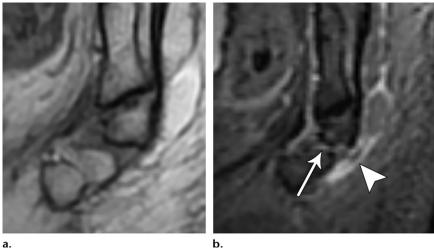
Endplate change in a 34-year-old woman. Sagittal T1-weighted (a) and coronal oblique T2-weighted fat-suppressed (b) images show dorsal subluxation of the coccyx at the first intercoccygeal joint (red dotted line) with T1 marrow hypointensity (arrow) in the second coccygeal body bordering this joint, which corresponds to T2 hyperintensity (arrowhead) at the same site, indicating edema.
